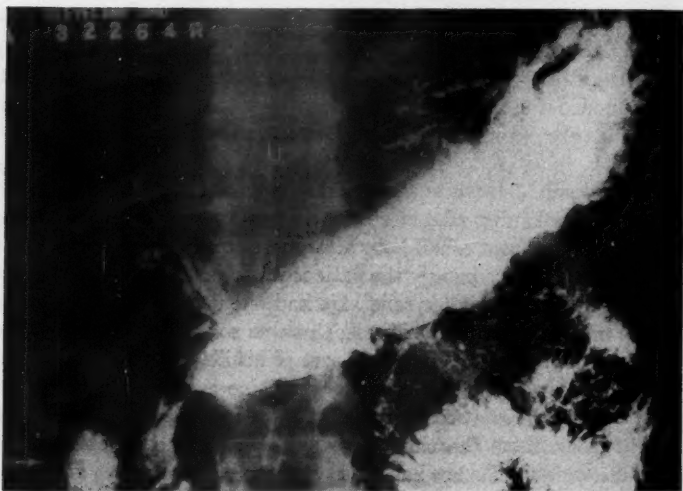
(R. T.) Anteroposterior roentgenogram showing barium in stomach, duodenum, and biliary duct system. Arrow points to barium in gallbladder.
